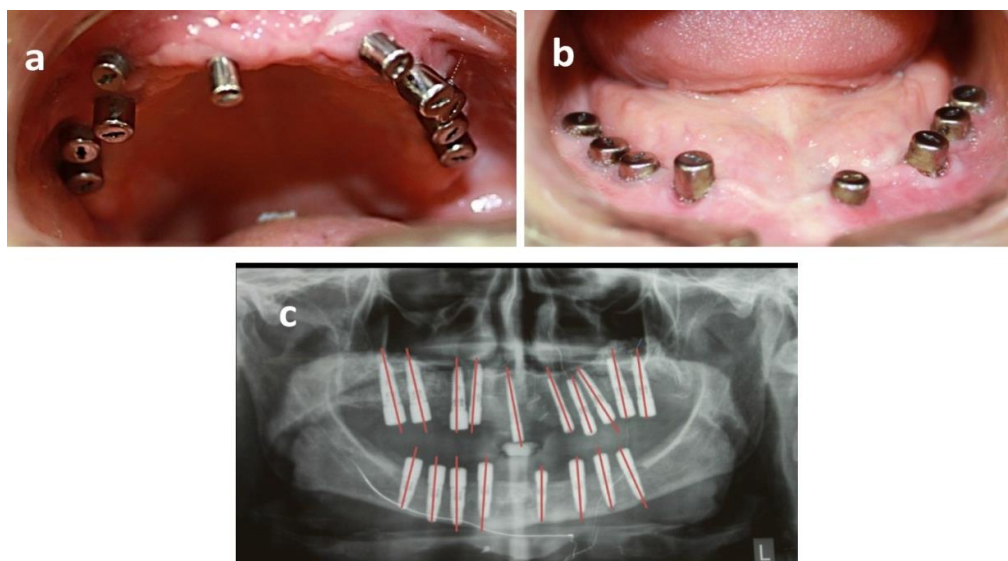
Pre-prosthetic examination: a) maxillary view b) mandibular view c) radiographic view
